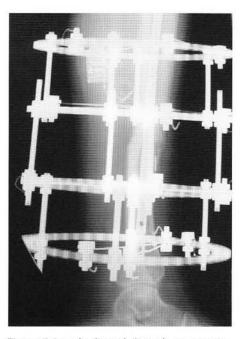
Lateral radiograph 4 months postoperative.
